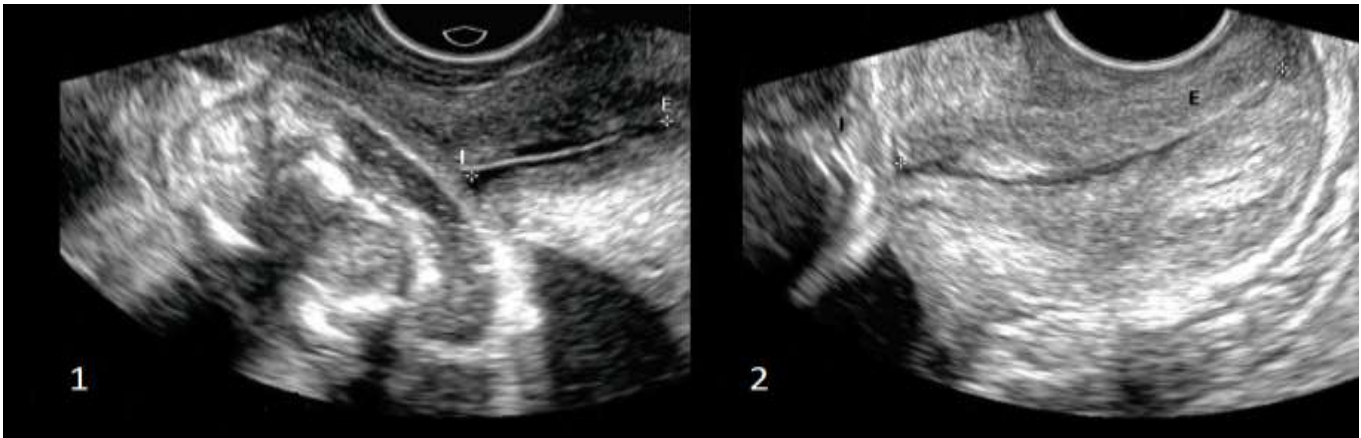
A transvaginal ultrasound image showing how cervical length is measured. The length is the distance between the inner opening (I) and outer opening (E) of the cervix.
